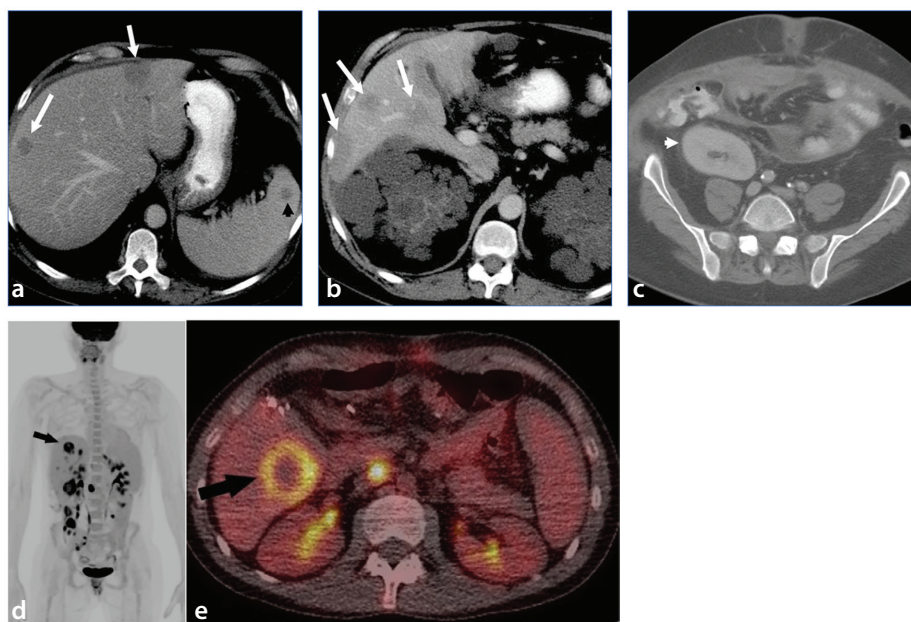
Axial contrast-enhanced computed tomography (CT) images in a 55-year-old man who had undergone renal transplant (short white arrow) 2 years earlier due to autosomal dominant polycystic renal disease and presented with abdominal pain and diarrhea. A contrast-enhanced CT scan (a-c) shows multiple hypoattenuating liver masses (long white arrows) and splenomegaly with one hypoattenuating splenic mass (black arrow). An fluorodeoxyglucose-positron emission tomography/CT scan (d, e) demonstrates uptake (black arrows) in another case of post-transplant lymphoproliferative disorder.
